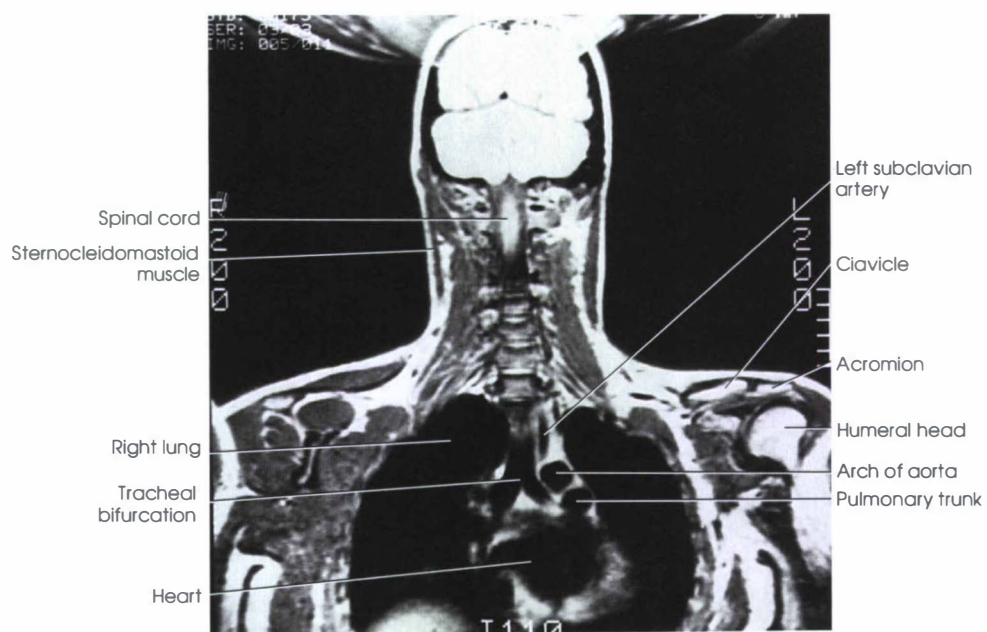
MRI of neck and thorax through midcoronal plane.
